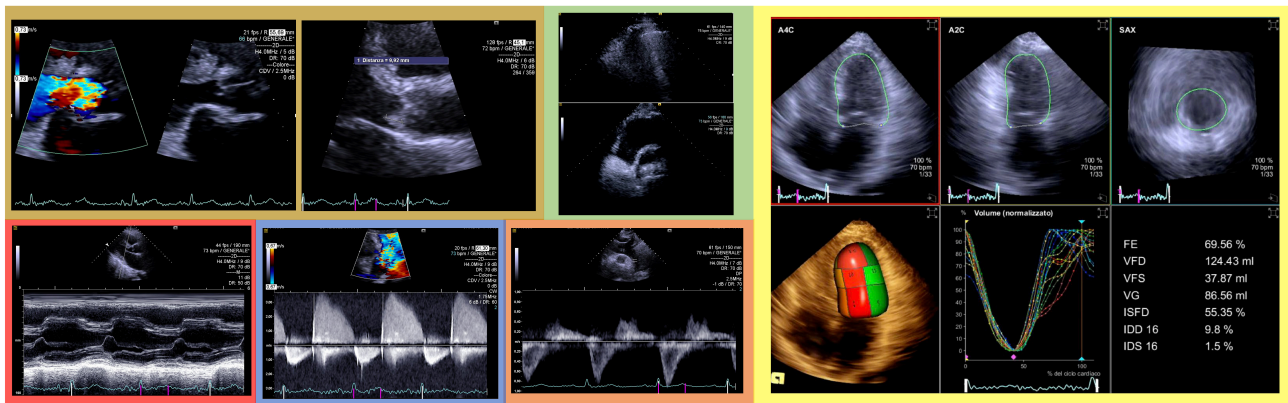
Brown squares: on the left, Color Doppler shows aortic regurgitant jet width/left ventricular outflow tract that approaches 100% and vena contracta = 2 cm; on the right, vegetation adhering to the non-coronary cusp is evident with a maximum longitudinal diameter of 9 mm. Green square: thoracic ultrasound demonstrates indirect signs of severe pulmonary congestion with a cardiogenic pattern (confluent b-lines in the upper part and pleural effusion in the lower position). Red square: M-mode echocardiography showing grade I early closure of the mitral valve with diminished A wave. Blue square: continuous-wave Doppler showing pressure half-time of 95 milliseconds. Orange square: pulsed-wave Doppler showing holo-diastolic flow reversal in the descending aorta. Yellow square: transthoracic real-time 3D demonstrates the absence of significant remodeling of the left ventricle (normal left ventricular volume: VFD) compatible with acute aortic valve regurgitation and an ejection fraction (FE) and stroke volume (VG) still within normal limits. 3D, three-dimensional; FE, ejection fraction; VFD, end-diastolic volume; VFS, end-systolic volume; VG, stroke volume; ISFD, end diastolic sphericity index; IDD 16, diastolic dyssynchrony index (16 segment model); IDS 16, systolic dyssynchrony index (16 segment model).
